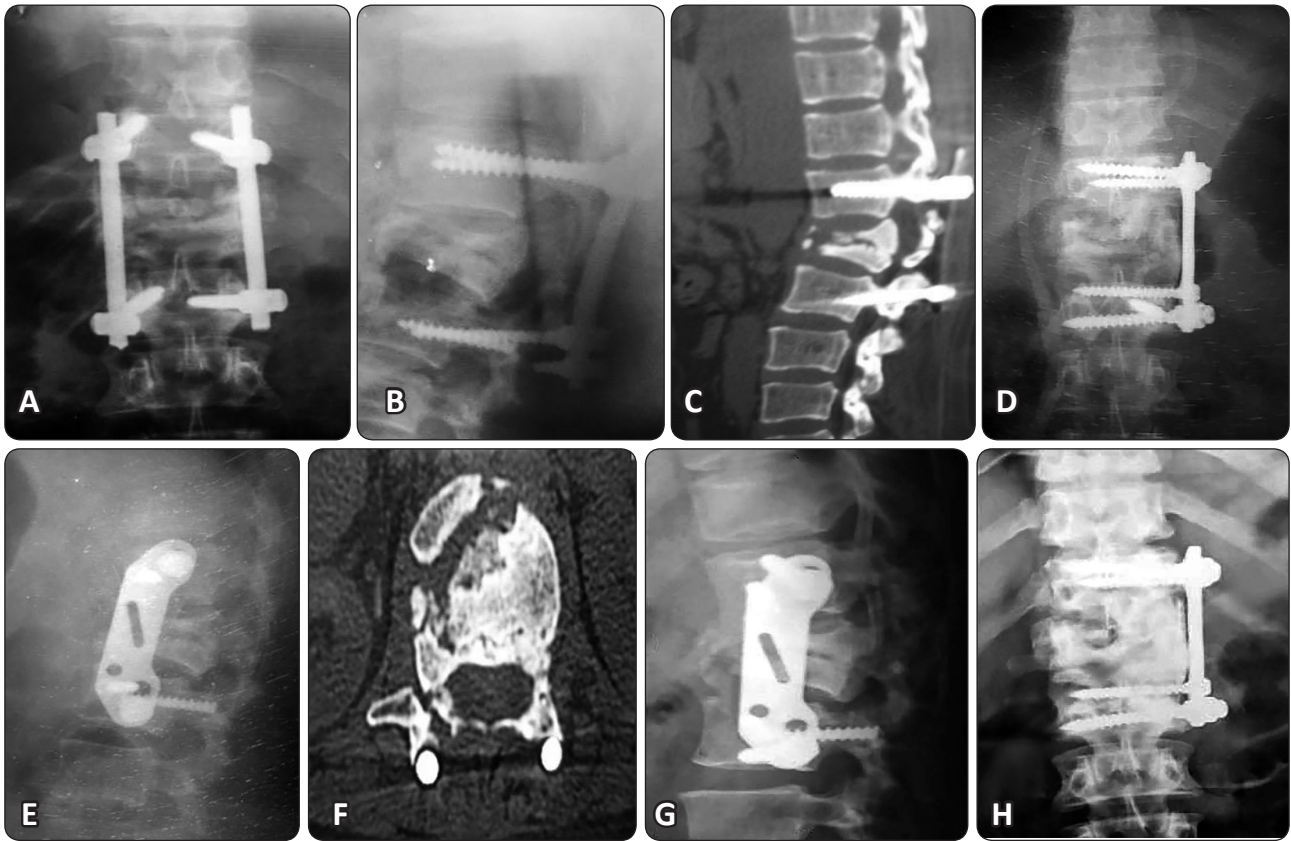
Female patient, 50 years old, Frankel E, with failed short segment pedicular fixation of L1 fracture, 15months since primary surgery. Preoperative plain X ray: anteroposterior (a) and lateral (b), Preoperative CT: sagittal (c) and axial (d) show pseudoarthrosis. Postoperative plain X ray: anteroposterior (e) and lateral (f) show anterior locked plate fixation with anterior corpectomy and strut iliac graft. Latest follow up plain X ray: anteroposterior (g) and lateral (h) show good fusion.
